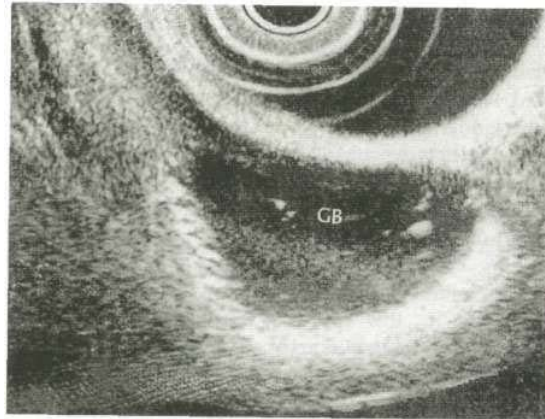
An endoscopic ultrasound scan with the probe within the duodenum (upper margin of the figure) clearly demonstrating the gall bladder (GB) with multiple small stones within.
